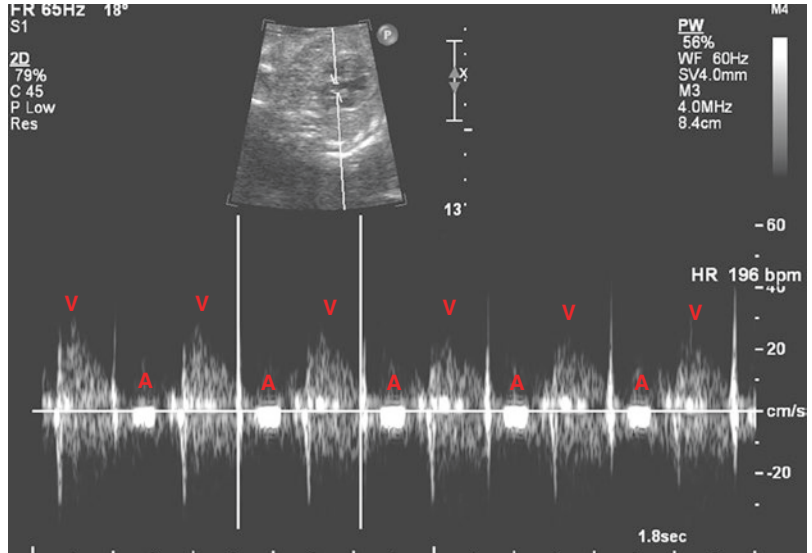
SVC–aorta Doppler showing PJRT in the fetus at a rate of 196 bpm. PFRT can be difficult to distinguish from AET or a normal rate and rhythm
